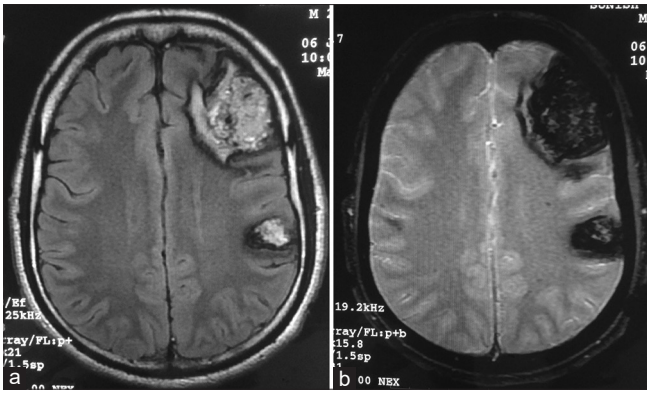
(a) Axial T2 FLAIR MR image demonstrating multifocal cortical based heterogeneously intense lesions in the left fronto-parietal lobes. (b) Axial GRE image demonstrating dense blooming in the cortical based fronto-parietal lobe lesions
